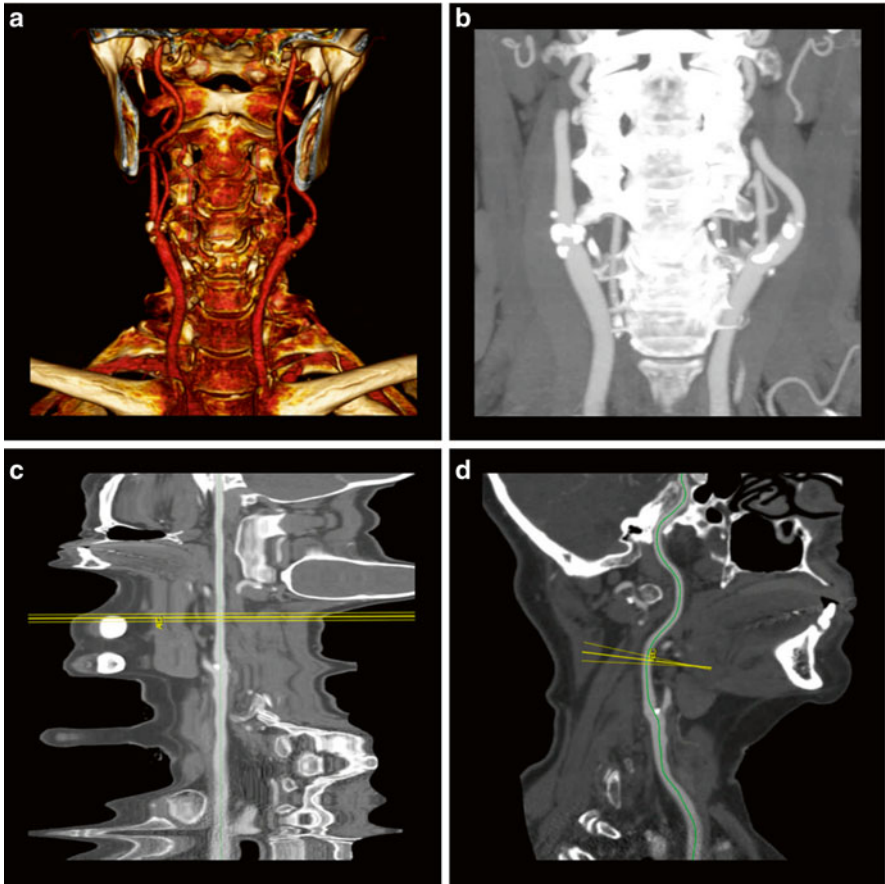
73-year-old female presenting with stroke-like symptoms. (a) A coronal orientation 3D volume rendering reveals bilateral calcified plaque at the carotid bifurcations, but does not allow for accurate assessment of the degree of stenosis. (b) A coronal orientation CTA MIP also displays the presence of calcified plaque but offers little information on the effects on the underlying artery lumen. (c) A “straightened” curved MPR CTA image of the left carotid artery shows that the atherosclerotic plaque has negligible effects on the vessel lumen. (d) A “stretched” curved MPR CTA image from the same dataset provides another view of the left common carotid artery with display of the centerline from the aortic arch through to the ipsilateral middle cerebral artery
